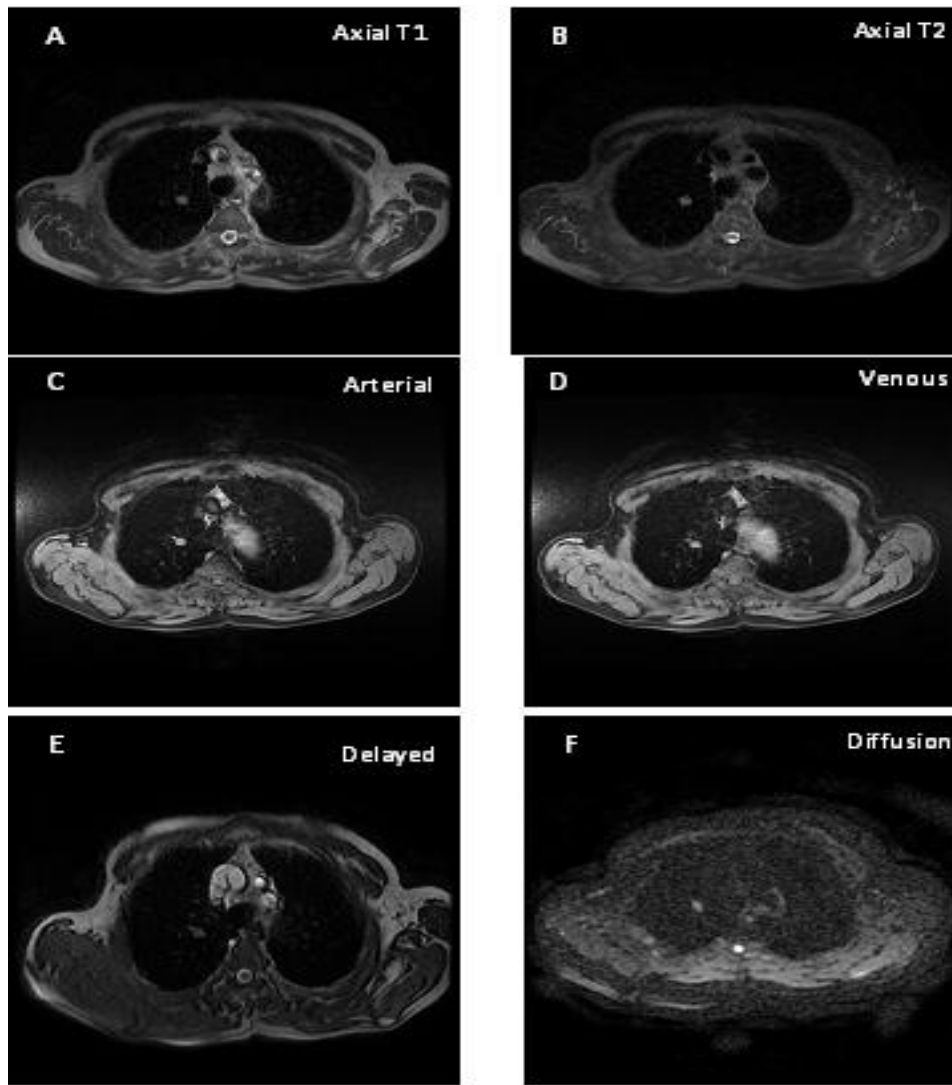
Case number 1. Right upper lung lobe solitary pulmonary nodule with speculated margin measures about (1.4x1 cm) seen displacing isointense signal at T1 (A) &T2 (B), in addition to pretracheal LN about 1 cm. While after dynamic post contrast phases that lasts for 4 minutes the nodule showing homogenous enhancement at arterial phase (C) and washout at portal (D)and delayed (E) phases. ADC value is $0.9 \times 10^{-3} \text{ mm}^2/\text{s}$ with restricted diffusion (F) (nodule is bright). The time-enhancement curve is of type A (G). CT examination showed solitary pulmonary nodule with speculated margin measures about (1.5x1 cm) seen at right upper lung lobe
